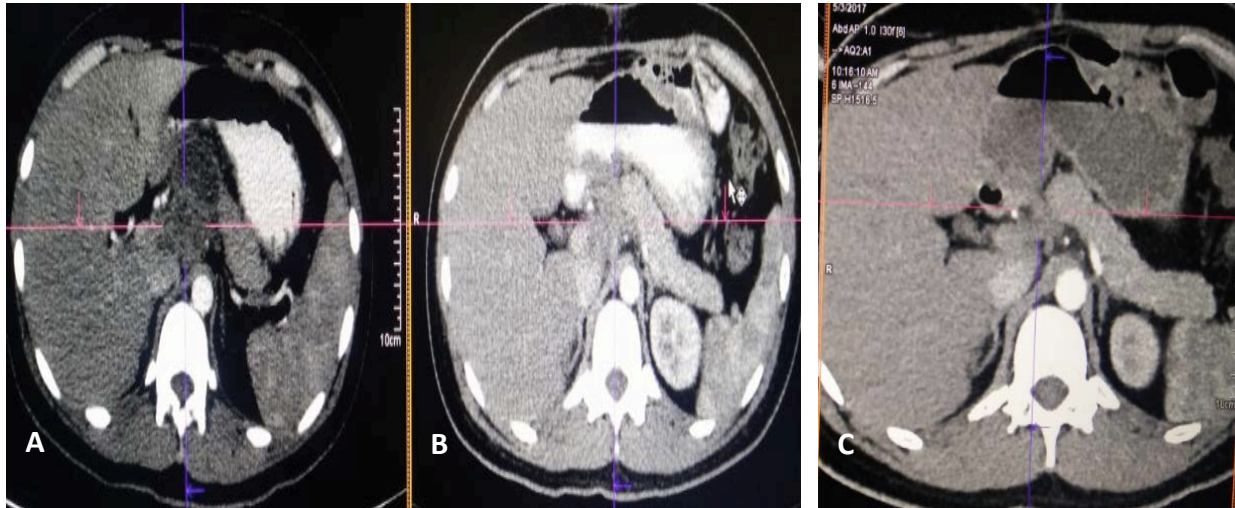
Repeat contrast enhanced abdominal computed tomography scans during the course of antimycobacterial therapy (A→B→C), showed interval regression of pancreatic mass (red arrow) and lymphadenopathies, with good cleavage planes with the adjacent stomach and liver, and still encasing the common hepatic artery.
